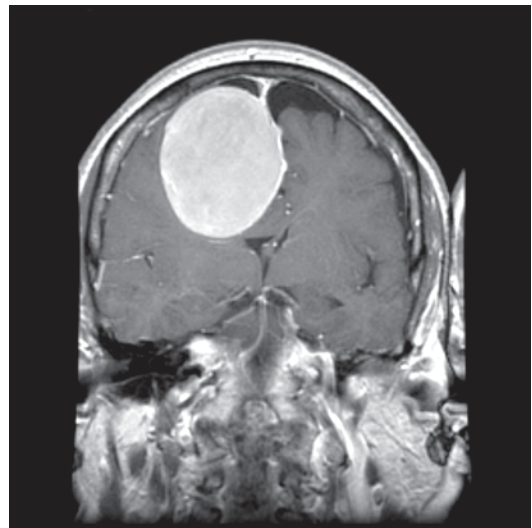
Coronal, T1-weighted MRI with gadolinium showing a very large parafalcine meningioma uniformly enhancing with no apparent surrounding edema. (Courtesy of Dr. Blaine Hart)
